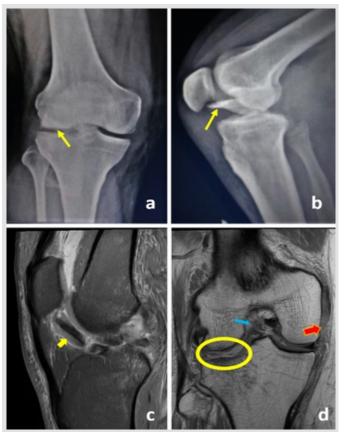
Pre-operative imaging of Case 2: (a and b) Plain radiographs showing the posterolateral tibial condyle fracture fragment (yellow arrow). (c) Magnetic resonance imaging scan proton-density fat-saturated sagittal section shows the osteochondral fragment lying anteriorly in the fat pad with cartilage surface facing inferiorly (yellow arrow). (d) Magnetic resonance imaging scan T1-weighted coronal section shows the tear of anterior cruciate ligament at femoral attachment (blue arrow), medial collateral ligament tear near femoral insertion (red arrow), and absence of lateral meniscus (yellow circle).
